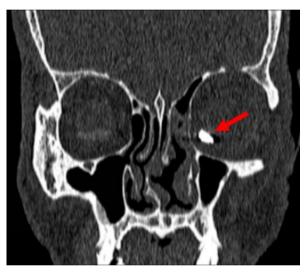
Repeated post-operative CT scan showing the remaining foreign body located inferomedial to the left globe (arrow)
